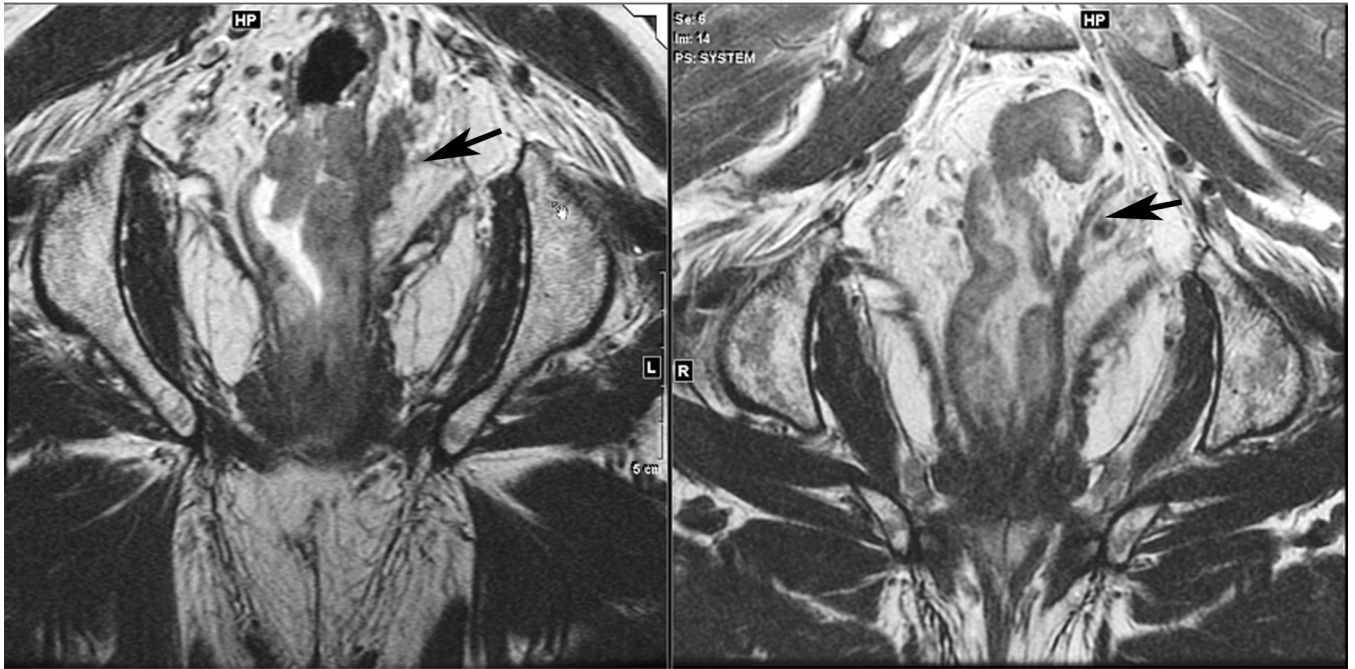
Coronal T2W pelvic MRI (A) pre and (B) post treatment in a 45 yr. old male with rectal cancer. The left sided EMVI is smaller and T2 darker indicating at least partial regression.
